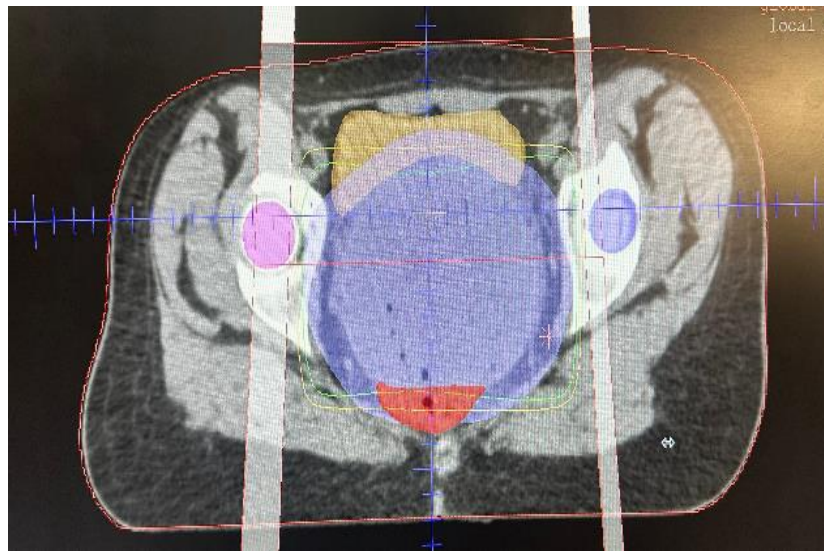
Axial CT slice of radiotherapy planning showing the contoured planning target volume (PTV, blue) and organs at risk: bladder (yellow), rectum (red), and femoral heads (purple). The isodose curves demonstrate appropriate coverage of the tumor
